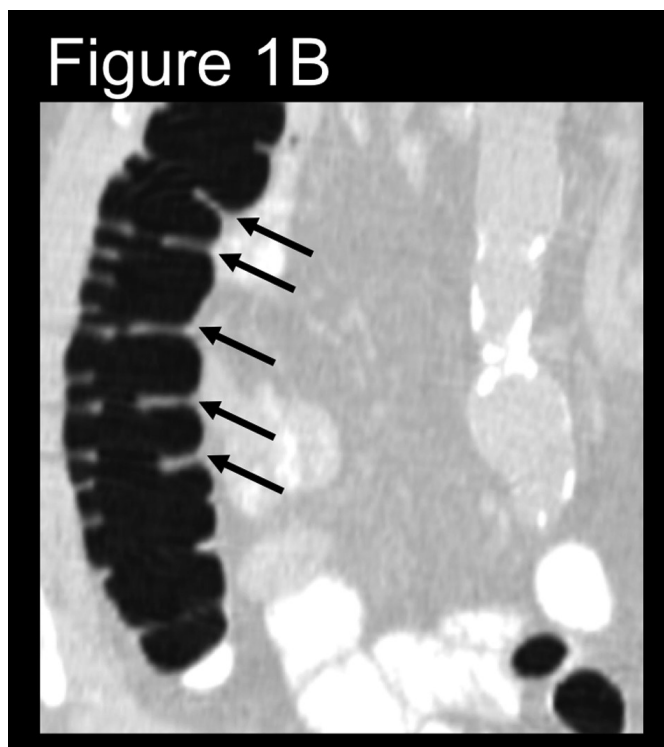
Coronal reformat demonstrating adequately distended ascending colon with at least five non-dependent haustral folds (black arrows) clearly visualized. (Multiplanar CT Colonography, Haustral Fold Selection, Axial).
